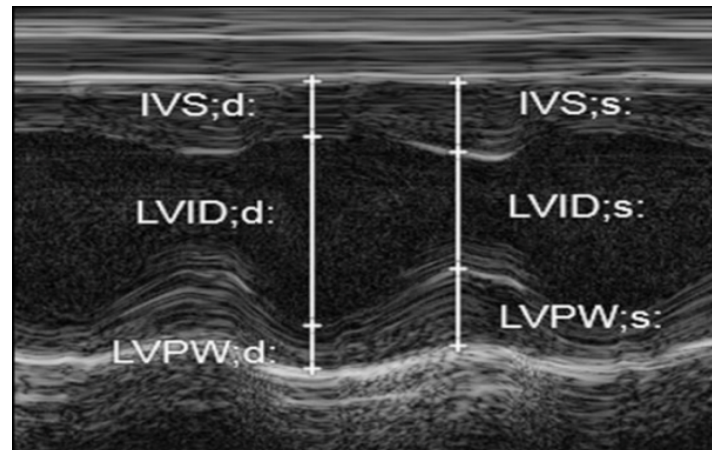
M-mode echocardiography analysis.
